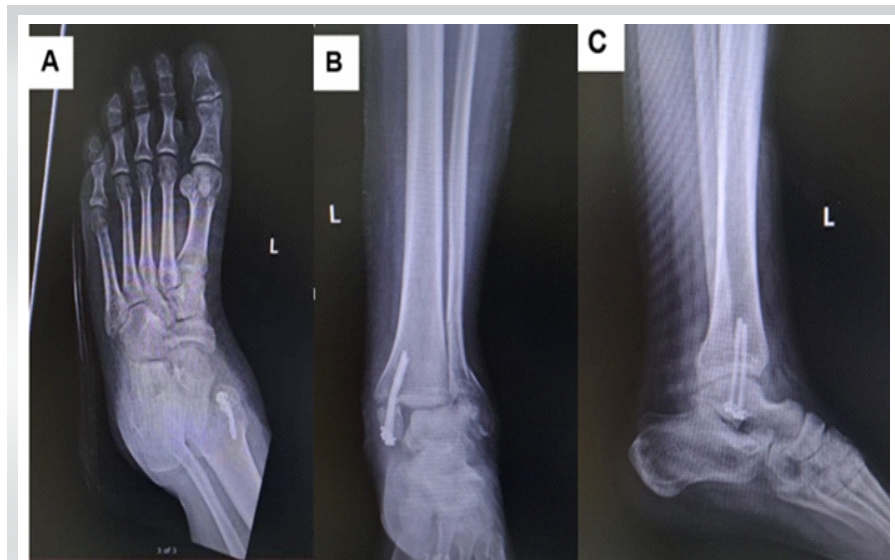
Pre-operative anteroposterior (a and b) and lateral (c) X-rays of the left ankle showing a bimalleolar fracture and bent medial malleolar screws with fracture non-union from previous fixation.
